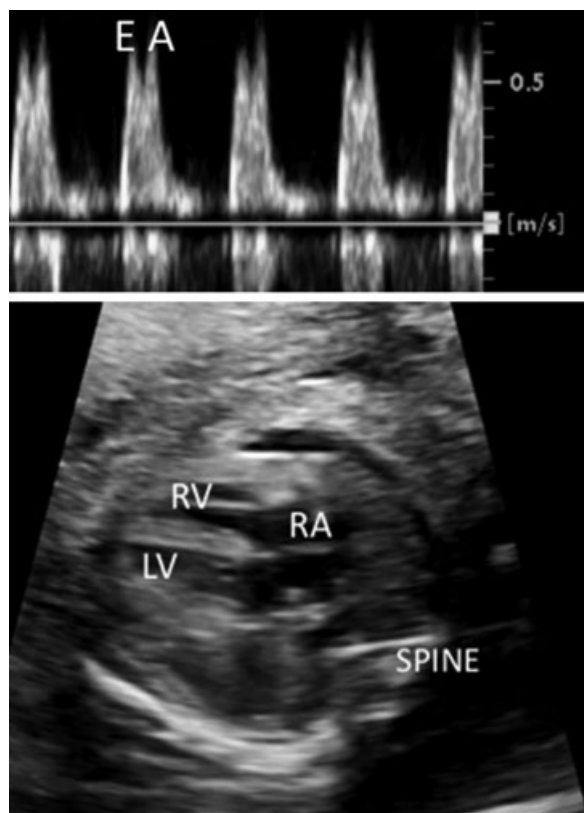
(Upper panel) Biventricular inflow Dopplers were abnormal with greater flow in early diastole (E) compared with late diastole atrial systole (A), potentially in keeping with abnormal myocardial diastolic function. (Lower panel) Four-chamber view of the heart demonstrating mild cardiomegaly associated with increased biventricular wall thickness or hypertrophy and no chamber dilation. The calculated combined cardiac output was normal for gestational age. LV, left ventricle; RA, right atrium; RV, right ventricle.
